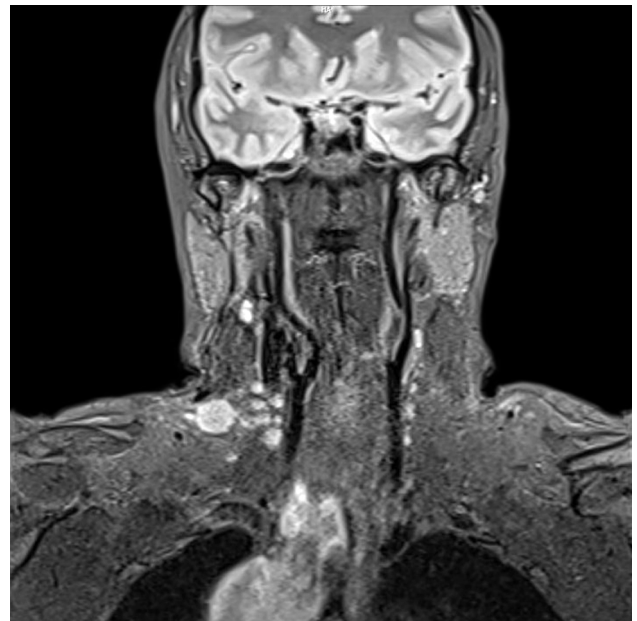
Magnetic resonance imaging of the bronchogenic cyst.
